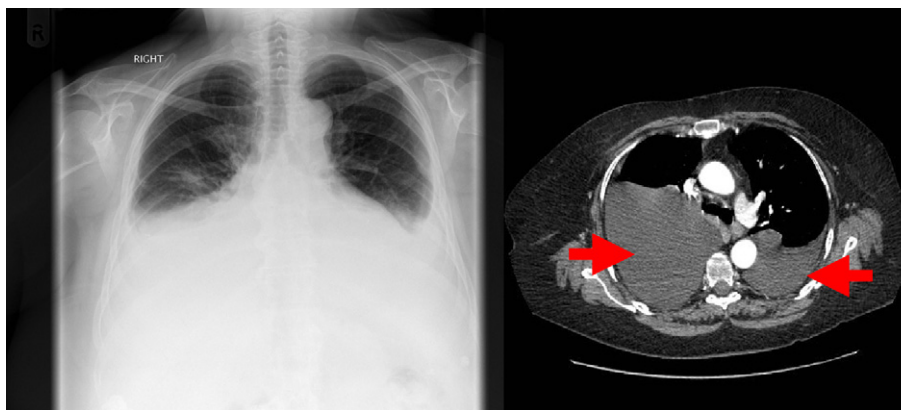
Chest X-ray and CT thorax demonstrating bilateral chylothorax.
